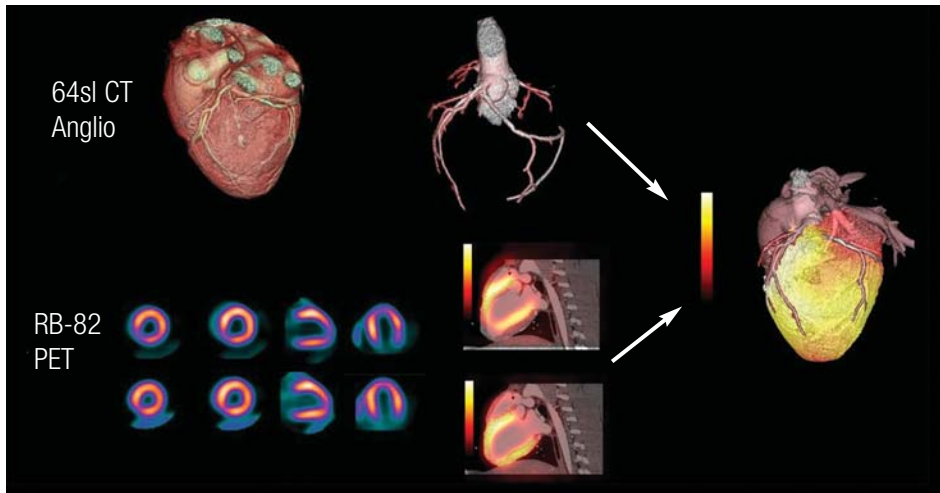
Fusion software for integrated analysis of PET and CTA. Coronary tree is separated from volumetric CT data (upper row, middle); PET data are fused and realigned to myocardium on CT images (lower row, middle); images are then merged again to 3D data set, which shows coronary tree morphology along with PET tissue perfusion superimposed to CT myocardial surface (right).
